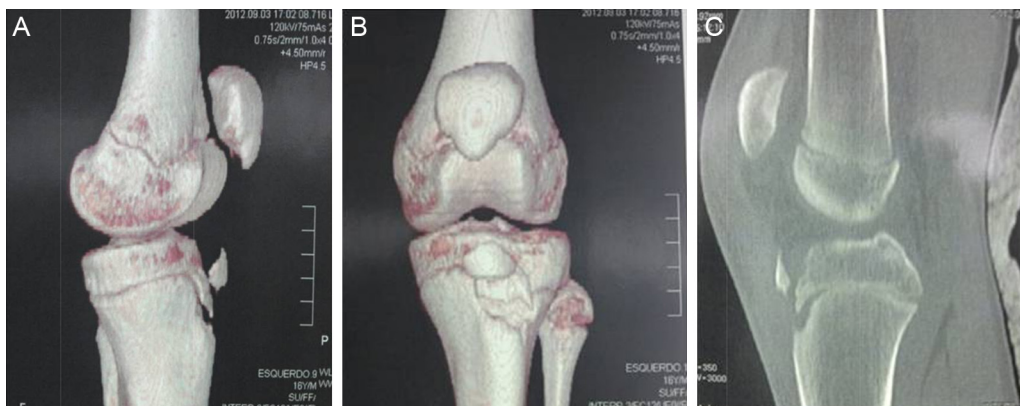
Computed tomography of the left knee, 3D reconstruction in profile (A) and anteroposterior view (B) showing avulsion of ATT and sagittal view (C) with type 1 injury according to the Watson-Jones classification.
